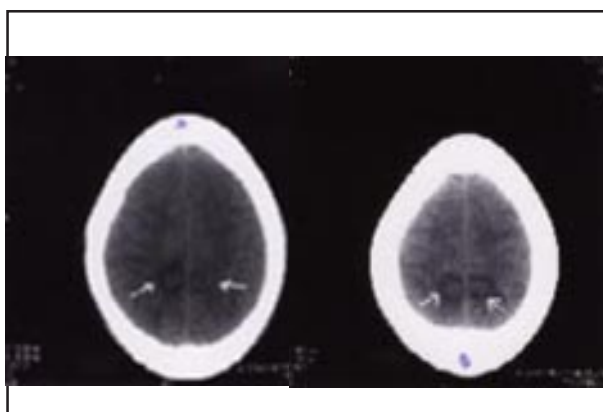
a, b: Non-contrast Cranial CT scan showing bilateral posterior parieto-occipital white matter hypodensities.
